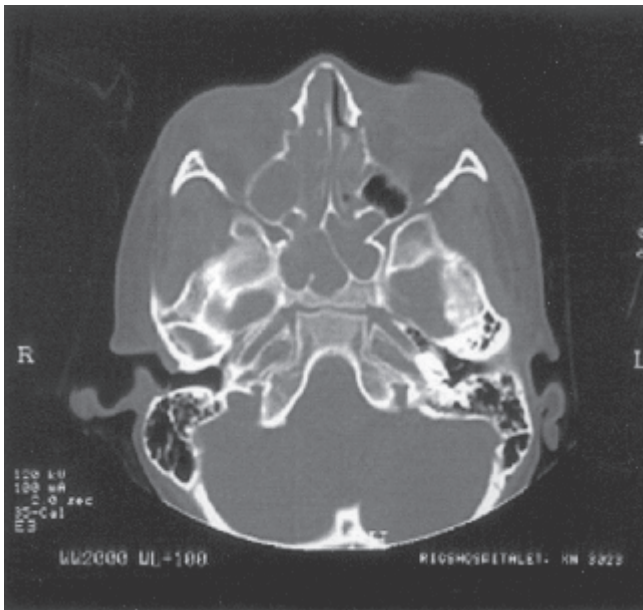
Preoperative CT demonstrating pansinusitis.
